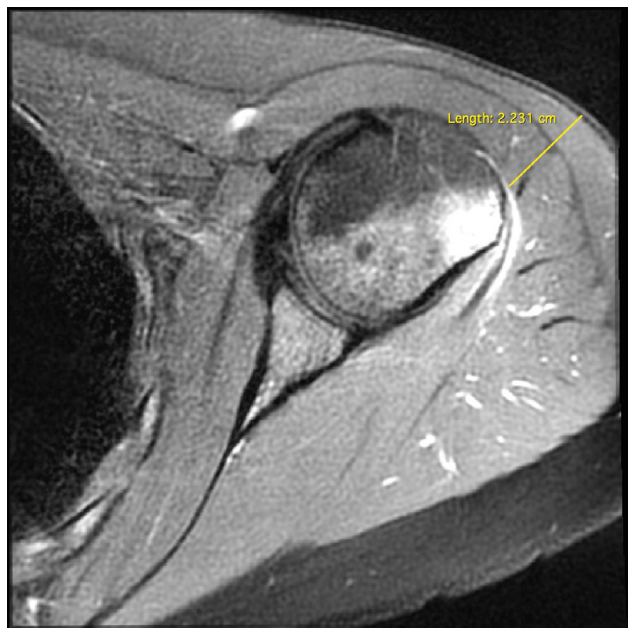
Case 1. Axial proton-density T2-weighted fat-saturated MRI demonstrating humeral head edema. Yellow line measures the estimated distance between the humeral head and skin surface.
